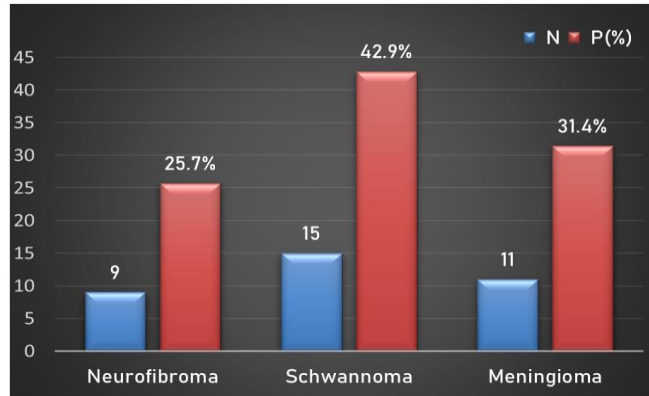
Distribution of intradural extramedullary spinal tumors based on MRI diagnosis
